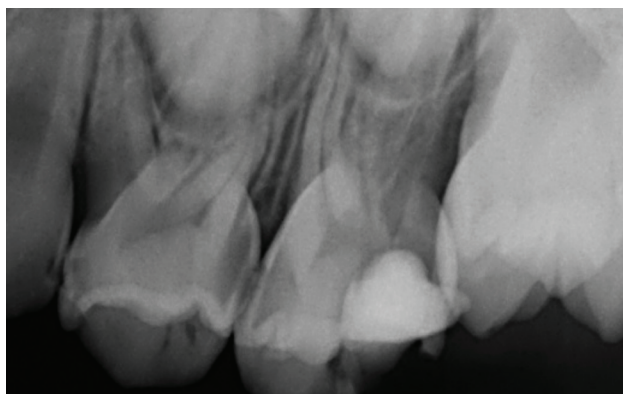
Periapical radiograph of upper left maxillary dentition showing interproximal decay with encroachment of the pulp of tooth 64. The tooth was previously treated by means of Atraumatic Restorative Technique (ART).
